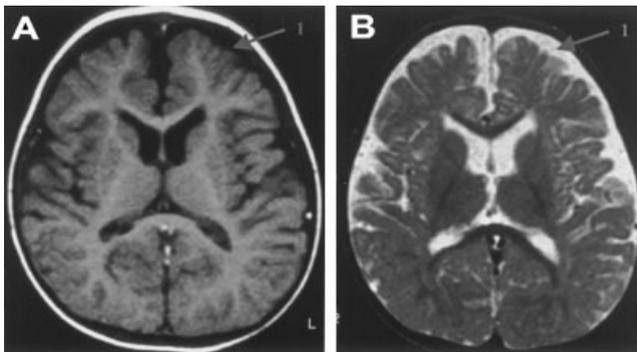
Magnetic resonance images from the proband. A: T1-weighted image. B: T2-weighted image. Both are axial slices from Spin Echo sequences. The enlarged CSF space and rounded ventricle suggest mild atrophy (arrow 1).
